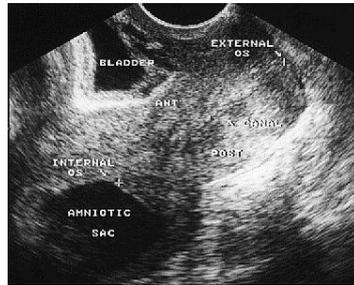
Transvaginal ultrasound scan showing landmarks found for cervical length measurement with an optimized plane for scanning.
